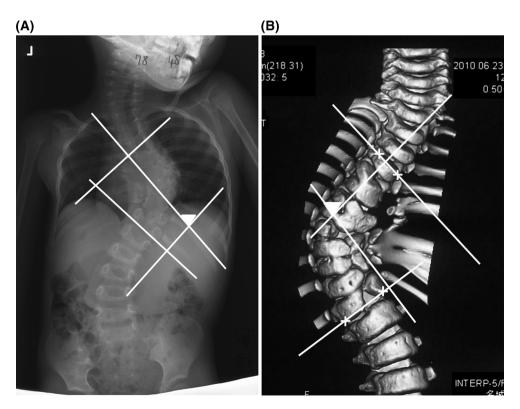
Measurements taken using the X-ray images (a) and 3D-CT images (b)
